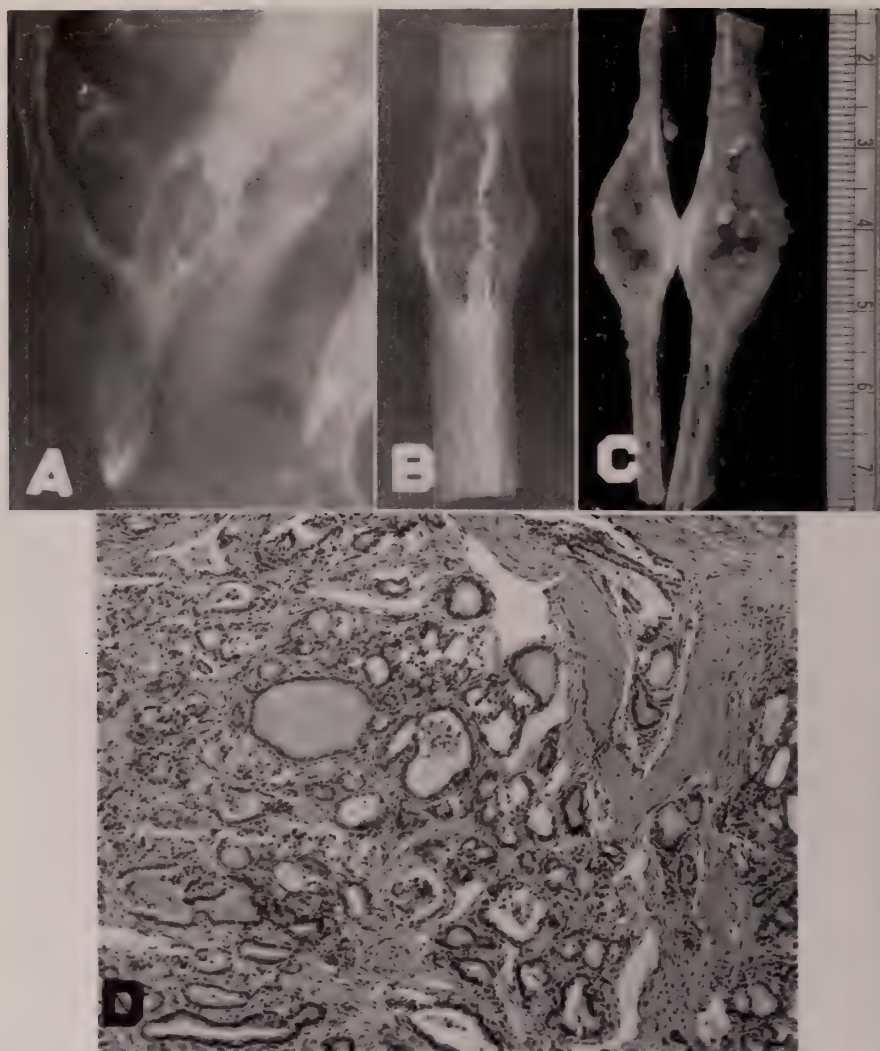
Case I*: Radiograph showing expanding, destructive, osteolytic lesion in right 11th rib.
